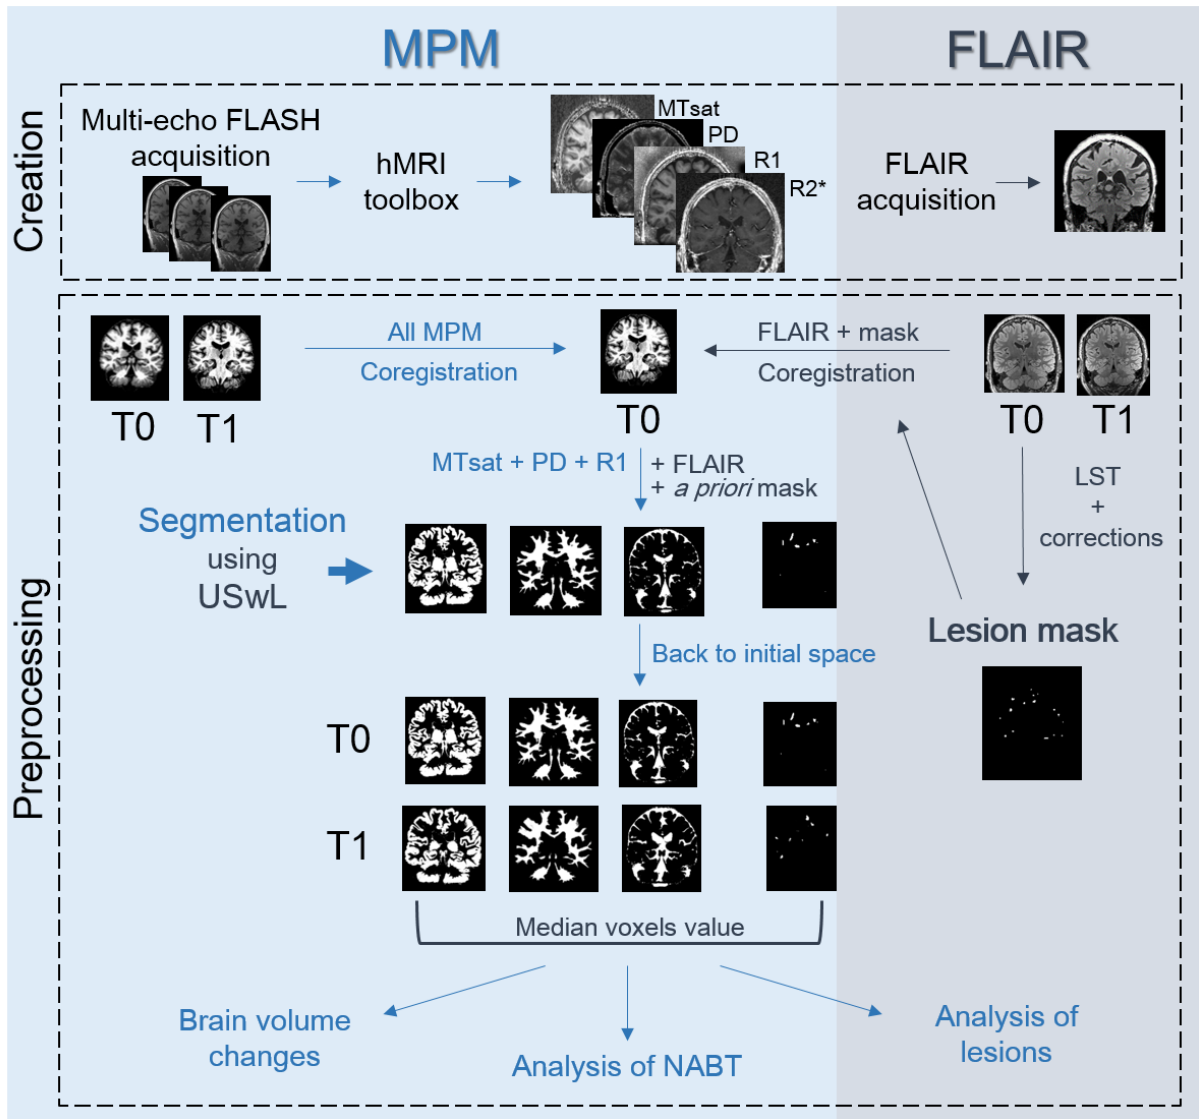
Chartflow of data creation and processing (see text). MPM maps were created with the hMRI-toolbox, FLAIR images were directly acquired for both sessions (T0 and T1). A preliminary mask was constructed based on T0 FLAIR. All images (MPM and FLAIR, T0 and T1) were co-registered to the MPM T0 space. Segmentation using USwL allowed to isolate the different tissue classes.
